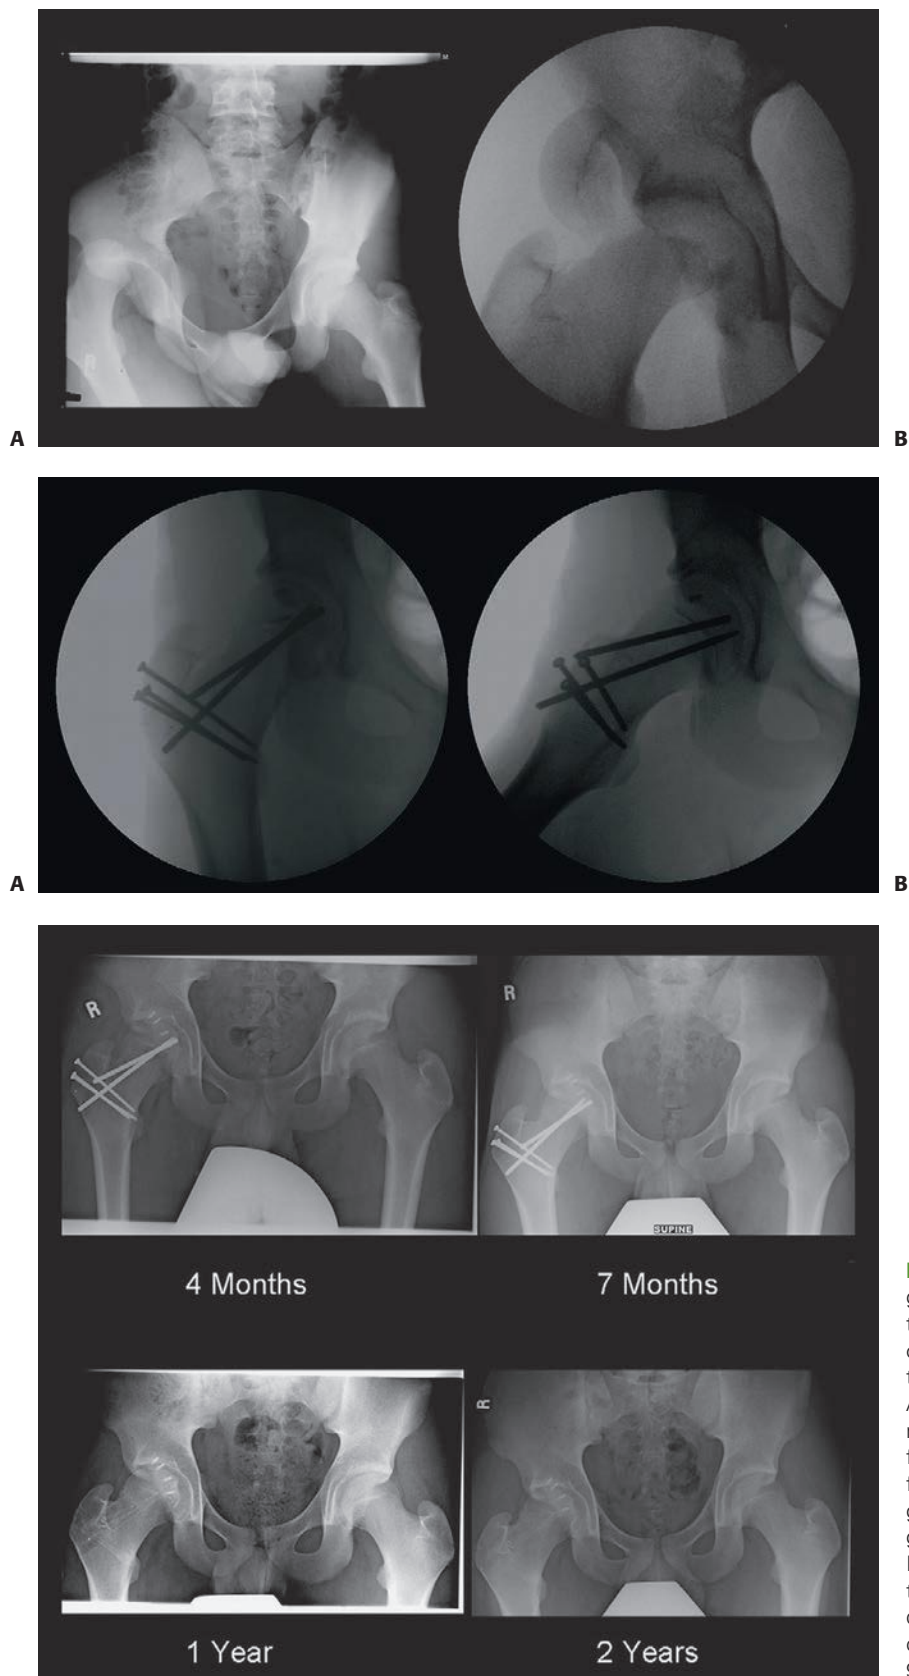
Top: A: Anteroposterior radiograph of the pelvis, showing dislocation of the right hip. B: Anteroposterior radiograph of the right hip, showing the physeal separation after attempted closed reduction. Middle: Anteroposterior (A) and lateral (B) radiographs made after surgical dislocation, reduction, and fixation of the epiphysis through a trochanteric flip osteotomy. Bottom: Anteroposterior radiographs made during the 2-year period after surgical reconstruction. (From Schoenecker JG, Kim Y, Ganz R. Treatment of traumatic separation of the proximal femoral epiphysis without development of osteonecrosis: A report of two cases. *J Bone Joint Surg Am.* 2010;92:973–977, with permission.)
